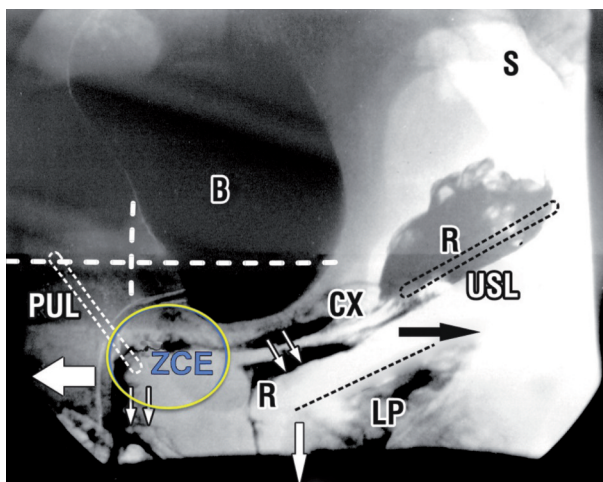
Xray Normal patient, sitting position, straining. Oppositely acting vector forces during straining (arrows) indicates the imperative of an elastic zone at ZCE so as to allow the vector closure forces to operate independently. Labelling as in 1A. CX = cervix; R = rectum; B = bladder; USL = uterosacral ligaments; S = sacrum.
